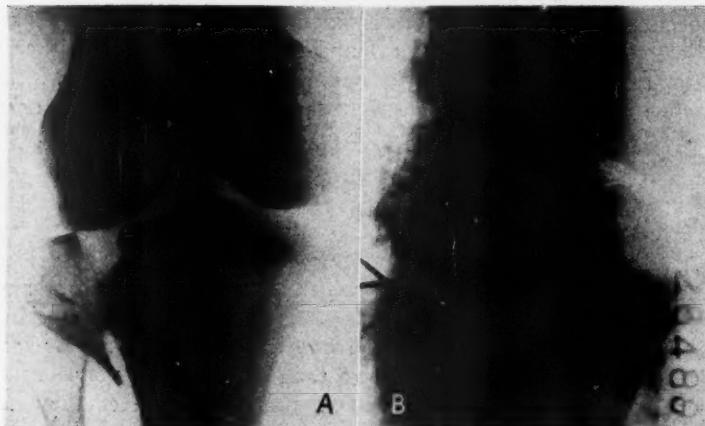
M. G. Male, 37. *A*. Fracture of external condyle of the right tibia. Small fragment of bone in the fracture line. *B*. X-ray after reduction. Small scrap of bone removed from between fragments and fracture perfectly reduced. Locked in place with crossed Kirschner wires. Wires removed at the end of 4 weeks. Excellent function.
